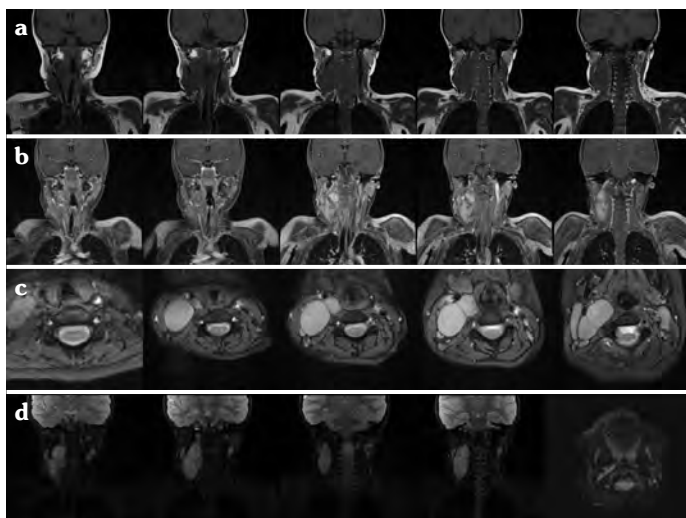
In the right parapharyngeal and prevertebral space, a mass is observed with an axial diameter of 37×40 mm and a craniocaudal diameter of 6 cm. In the A line, the tumor is observed hypointense in T1 weighted coronal sections, In the B line, the tumor is observed in fat suppression T1 weighted coronal sections. In the C line, the axial view of the tumor is observed. The tumor is located posterior to vascular structures and hyperintense in T2 weighted MRI sections. In the D line, the tumor is observed hyperintense in T2 weighted coronal sections and the last axial T2 weighted section, the tumor is extending through to the skull base is observed
